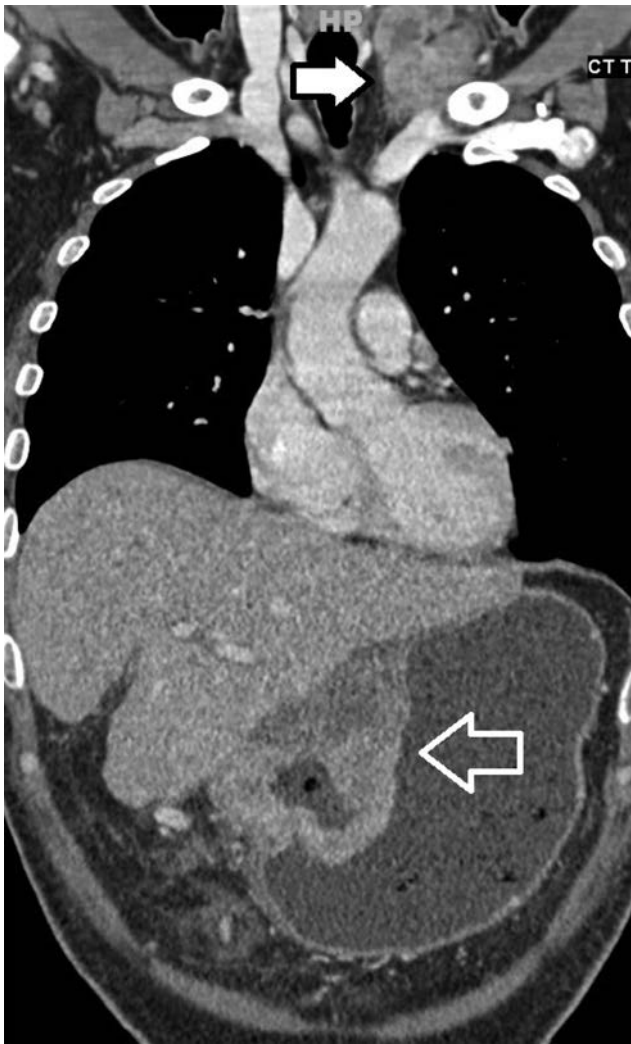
Virchow node. Coronal reformatted contrast enhanced computed tomography of thorax and upper abdomen showing large tumor in the lesser curvature of stomach (open arrow). Left supraclavicular fossa shows a lobulated heterogeneously enhancing nodal mass (solid arrow).
